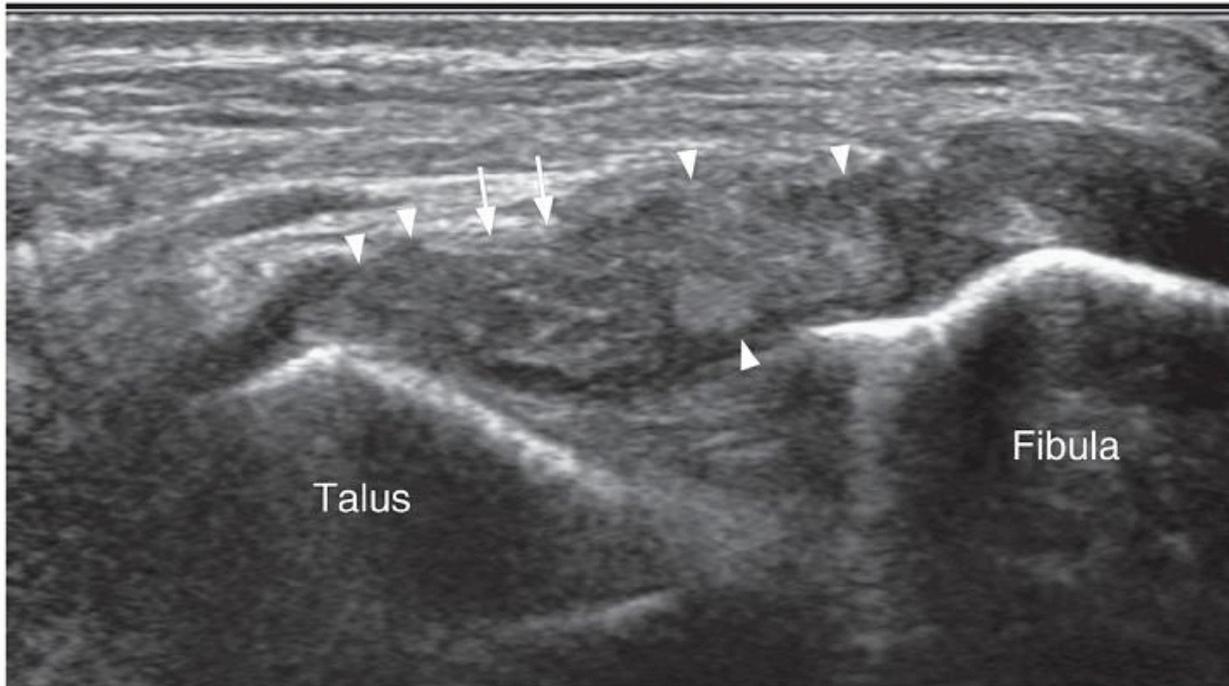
Longitudinal ultrasound lateral aspect of ankle showing complete tear of ATFL. The ligament (arrowheads) is very swollen with a complete tear (arrows) close to the talar attachment.
